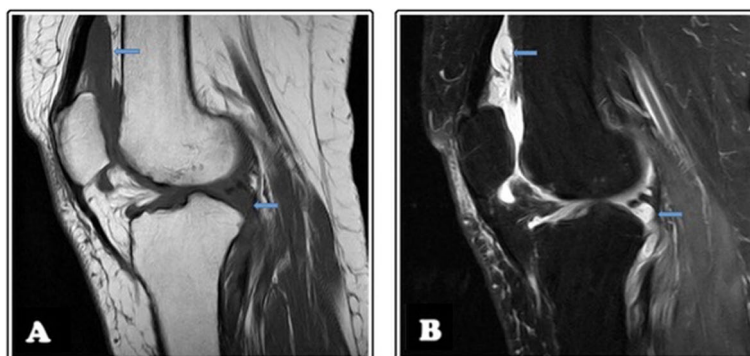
MRI after 22 months of treatment with tocilizumab. Sagittal T1-w FSE image (A) and FS PD-w FSE image (B). Complete disappearance of amyloid deposits. Only mild synovial thickening and effusion are seen (arrows)
